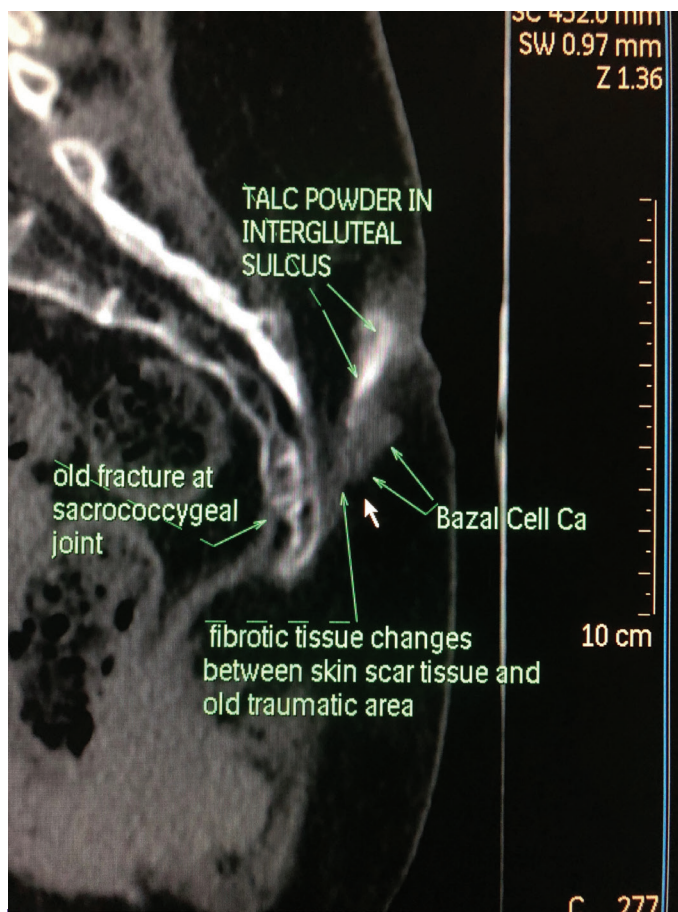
Sagittal computed tomography of the pelvis: Irregularities between skin scar tissue and old traumatic area (arrow), basal cell cancer (double arrow), old fracture at sacrococcygeal joint (stars), talc powder on the intergluteal sulcus (triple arrow)
